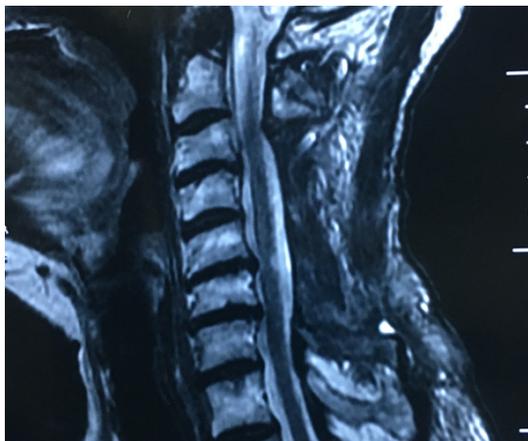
Compression of the spinal cord at C3-C4 and a myelomalacia focal at C5-C6 were revealed using sagittal MRI of the cervical spine at the one-month follow-up.
